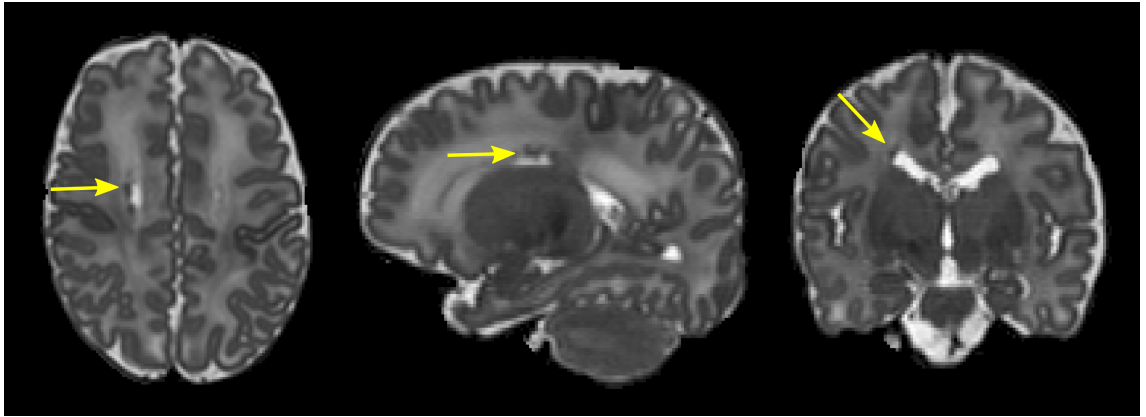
Axial, sagittal and coronal views of T2-weighted image of infant with small HPOI, indicated by the yellow arrows.
